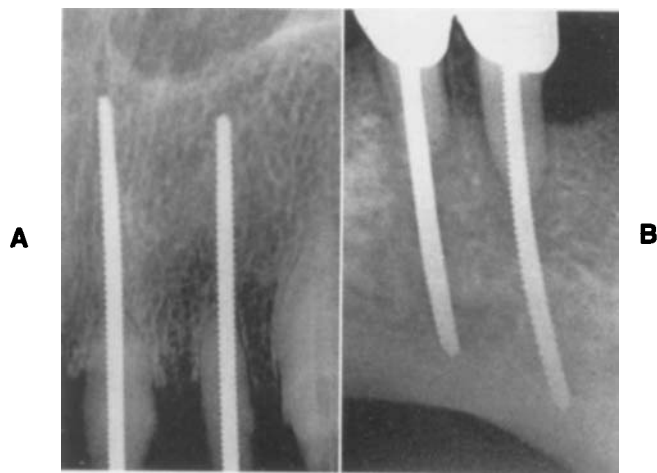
■ Periapical radiographs of endodontic stabilizers in maxilla (A) and mandible (B).
